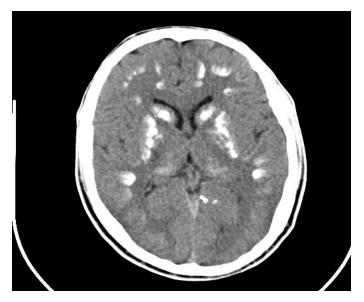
Plain CT Brain Showing dense symmetrical calcification of bilateral caudate and lent form nuclei His systemic examination was un remarkable Routine
